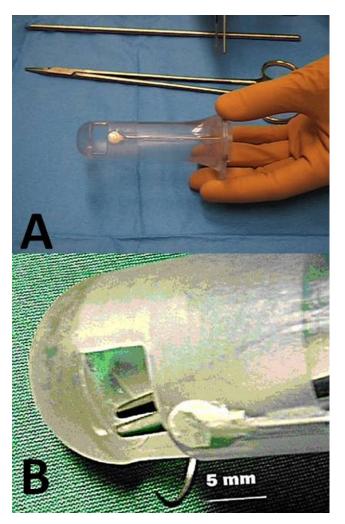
A. Overall view of the transparent rectoscope with the Doppler transducer at its end. B. Detailed view of the extremity of the rectoscope where the centimeter-sized window through which the ligations are accomplished, can be seen.
